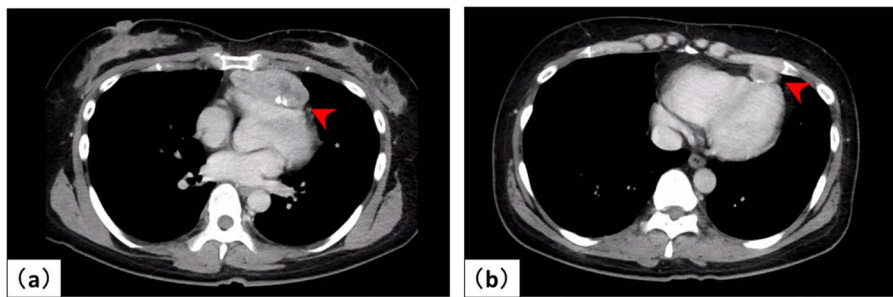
A 45-year-old woman presenting with multiple anterior mediastinal masses. (a, b) On contrast-enhanced computed tomography (CT), the masses demonstrated homogeneous enhancement with partial calcification (arrowheads).
